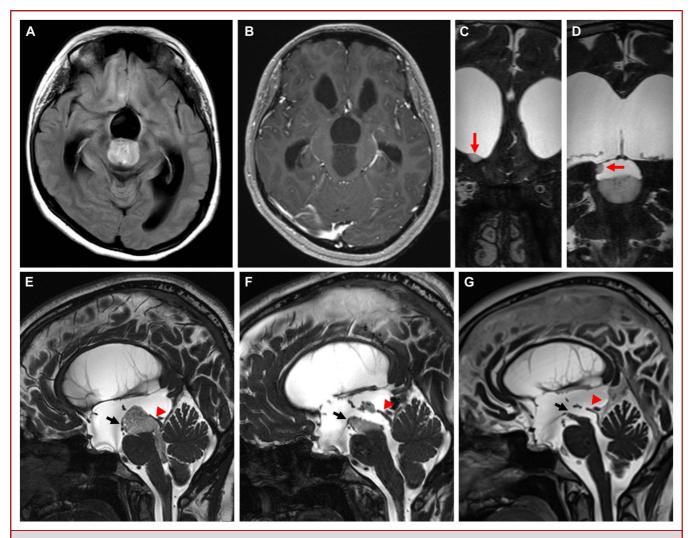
Magnetic resonance images showing an occupying mass inside the lumen of the aqueduct. A, Fluid-attenuated inversion recovery images after gadolinium enhancement. B, T1-weighted images after gadolinium enhancement. C and D, Multiple periventricular nodules suggesting cerebrospinal fluid dissemination are seen on coronal CISS images (red arrows). E, Sagittal CISS images showing an aqueductal tumor with an incarcerated mass toward the fourth ventricle. F, Aqueductal patency was secured immediately after the surgery. G, Complete tumor response and flattening of the third ventricle floor were obtained after completion of chemotherapy (18 months after surgery). The tegmentum of the midbrain was dislocated forward (black arrows). The tectum plate did not show neoplastic changes (red arrowheads). CISS, constructive interference in steady state.
